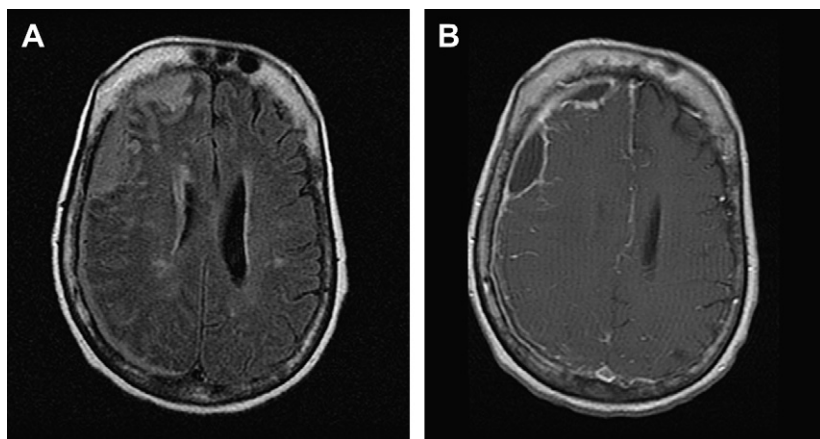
Patient with long-standing systemic lupus erythematosus on prednisone and azathioprine presented with headache and fever. MRI FLAIR (A) shows extradural signal hyperintensity layering along the subdural space. There is intense dural enhancement on the gadolinium image (B).
